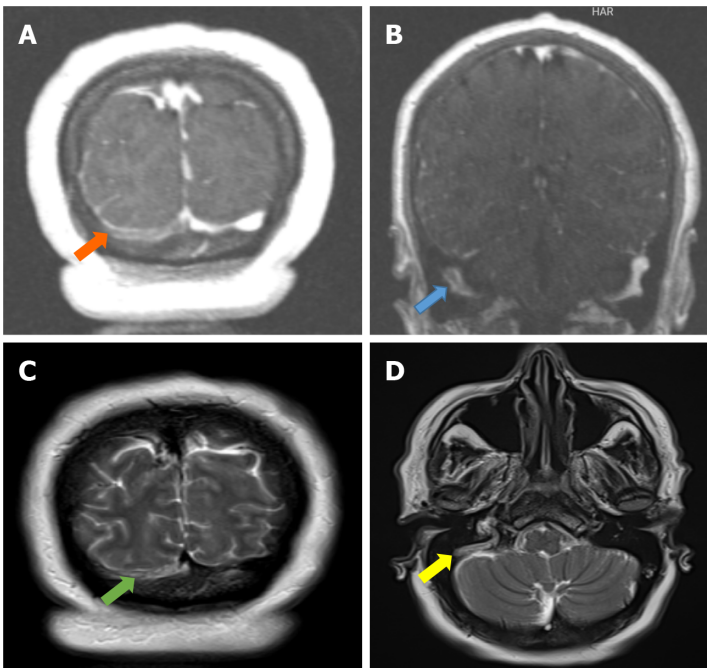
Lateral sinus thrombosis. A: The coronal post-contrast T1W cerebral magnetic resonance venography image shows loss of signal along the right transverse sinus (orange arrow); B: The coronal post-contrast T1W cerebral magnetic resonance venography image shows loss of signal along the right sigmoid sinus (blue arrow); C: The coronal T2W magnetic resonance image shows hyperintensity due to flow void loss in the right transverse sinus (green arrow); D: Axial T2W magnetic resonance image shows hyperintensity due to flow void loss in the right sigmoid sinus (yellow arrow).
